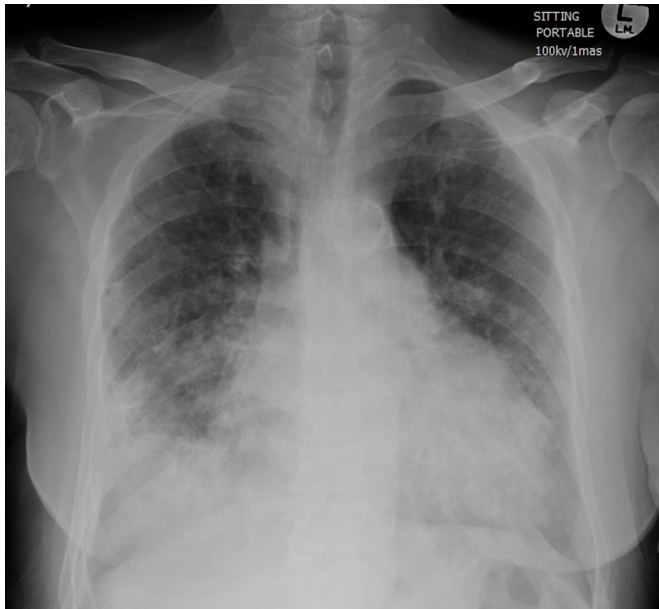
Chest X-ray on admission showed diffuse reticulo-nodular infiltrates with irregular opacity in the right lower zone.
